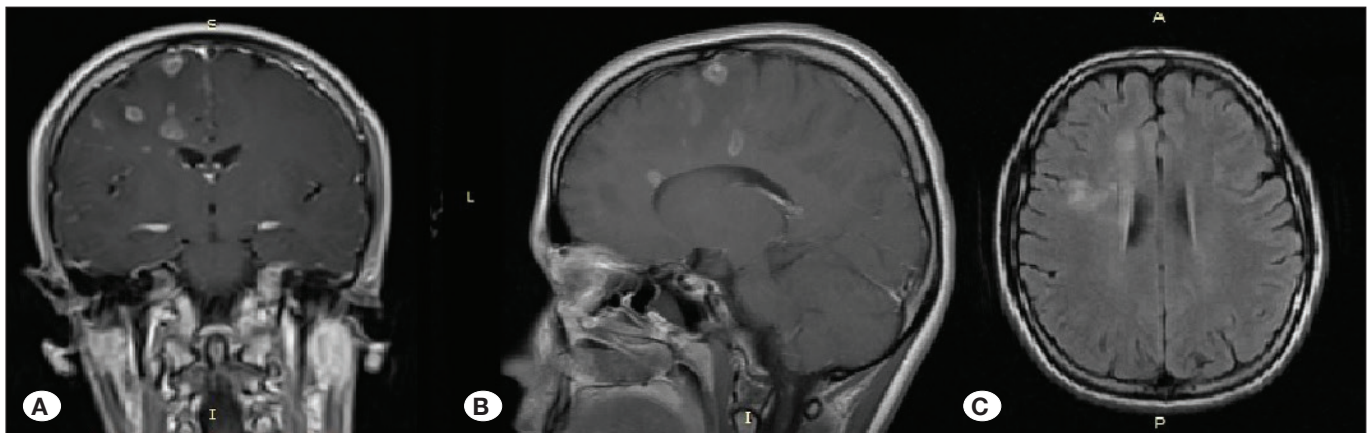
Multiple disseminated intrinsic frontal lesions with contrast enhancement on coronal (A), sagittal (B) and axial (C) MRI scans.
